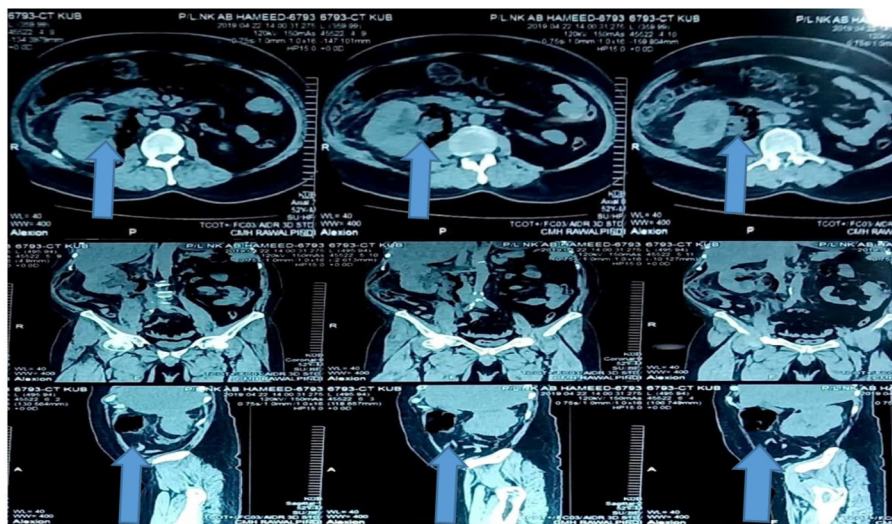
CT KUB axial film shows the presence of air in the collecting system of kidneys. Coronal & sagittal films show the air extending to the psoas muscle and diaphragm area.
